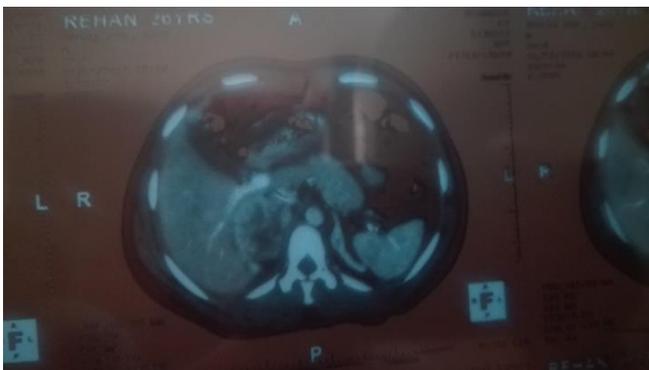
CT scan showed hypoplastic uterus, bilateral adrenal hyperplasia in the form of dense elongated mass with calcification.
